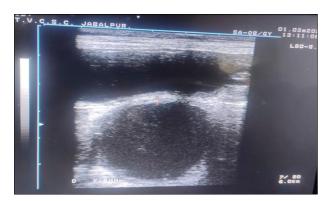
Ultrasound investigation after high temperature myocardial lesion
